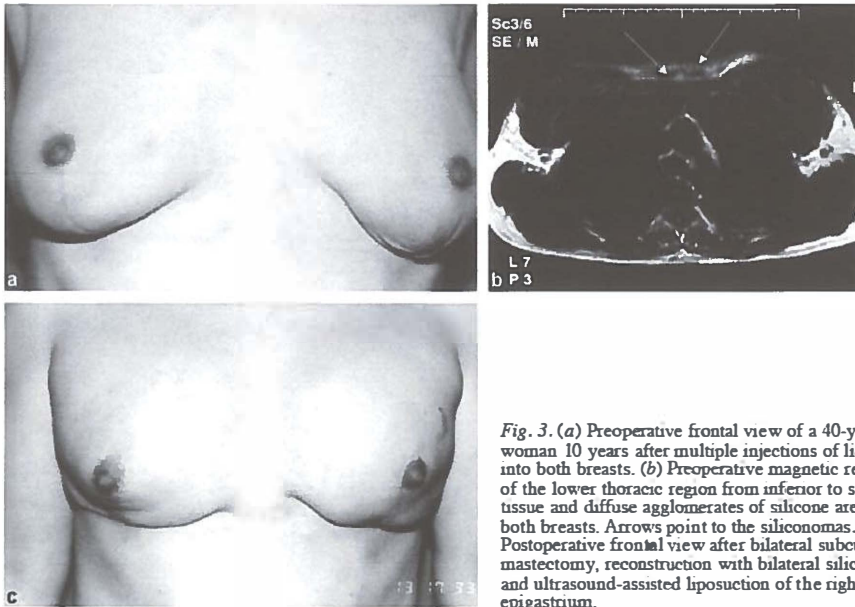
(a) Preoperative frontal view of a 40-year-old woman 10 years after multiple injections of liquid silicone into both breasts. (b) Preoperative magnetic resonance scan of the lower thoracic region from inferior to superior. Scar tissue and diffuse agglomerates of silicone are present in both breasts. Arrows point to the siliconomas. (c) Postoperative frontal view after bilateral subcutaneous mastectomy, reconstruction with bilateral silicone implants, and ultrasound-assisted liposuction of the right and left epigastrium.
